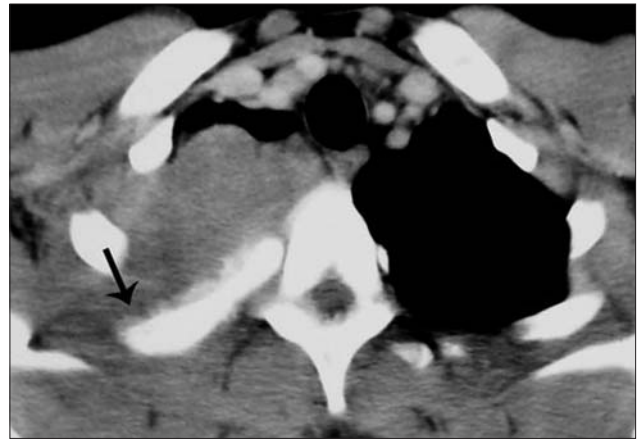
Axial contrast-enhanced CT section of the chest shows a large solid mass in the upper right hemithorax. Note the hyperostosis and backward displacement of the third rib (*arrow*).
